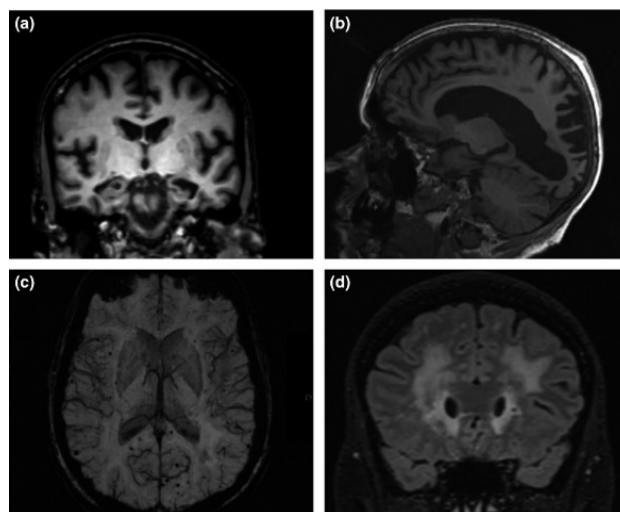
“MRI images showing (a) characteristic hippocampal atrophy in a typical Alzheimer's disease case best visualized in the coronal plane on T1; (b) parieto-occipital atrophy in a posterior cortical atrophy case, here demonstrated in the sagittal plane on T1; (c) microbleeds which are best visualized on SWI (the posterior distribution seen on this axial image is characteristic of cerebral amyloid angiopathy); (d) extensive periventricular and subcortical white matter hyperintensities best visualized on FLAIR, seen here on a coronal image.”
